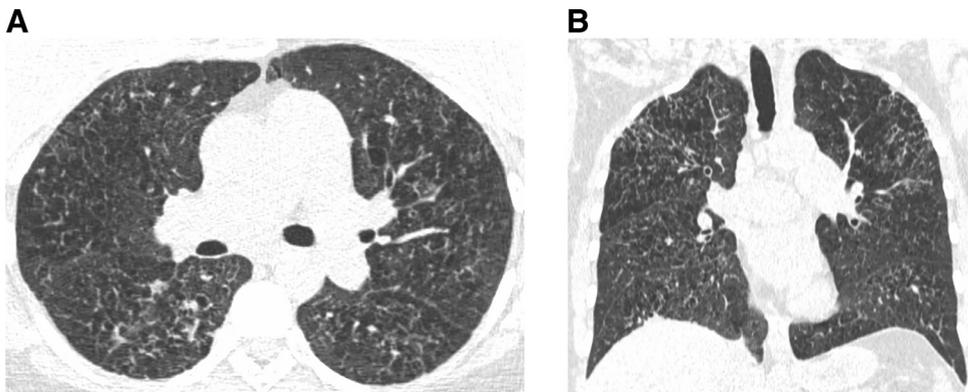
A 54-year-old female smoker with end-stage pulmonary Langerhans cell histiocytosis and pulmonary hypertension. Axial (A) and coronal reformatted (B) CT images show confluent upper lung predominant cysts mimicking emphysema. Central pulmonary arteries are enlarged. Note conspicuous sparing of the costophrenic sulci.
